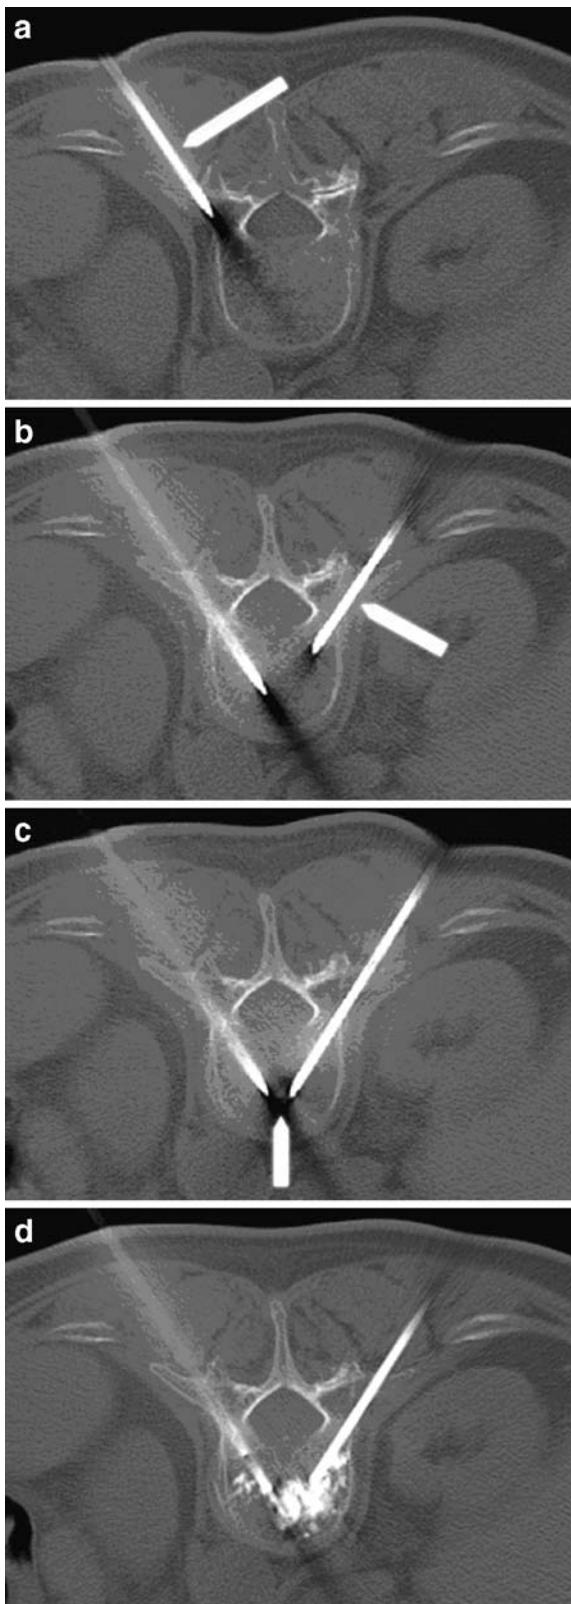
a Axial CT-scan is showing the transpedicular approach to the vertebral body (L1) using a vertebroplasty needle (arrow) b Axial CT-scan is showing the bipedicular approach to the vertebral body (L1) using a second vertebroplasty needle (arrow) c Axial CT-scan is showing the bipedicular approach to the vertebral body (L1). Note the arrow pointing to the central positioning of both needles in the anterior half of the vertebral body d Axial CT-scan is showing the filling of the vertebral body (L1) with bone cement. No bone cement leakage is detected
